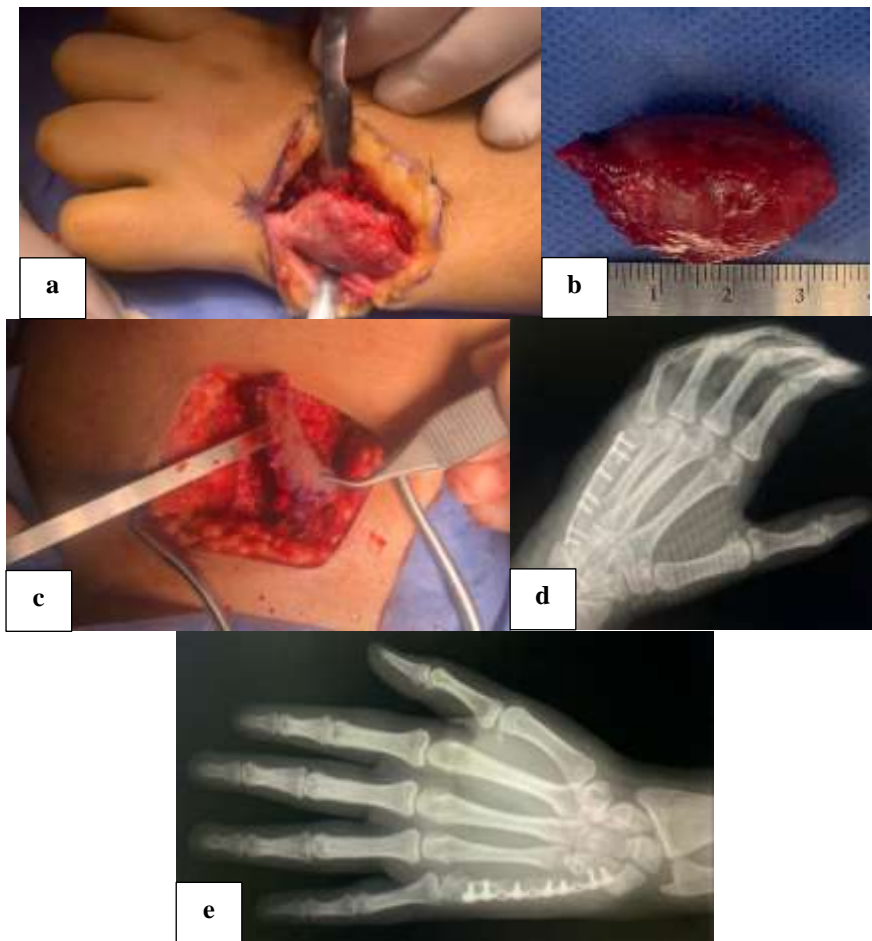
(a) The dorsal approach of the fifth metacarpal with exposure of the lesion; (b) resection of the proximal fifth metacarpal bone, 35×21 mm; (c) a iliac crest bone graft of 35×12 mm; (d and e) postoperative radiographs showing a ten-hole 2.0 system miniplate reducing the iliac bone graft with the distal fifth metacarpal and the Hamate.
